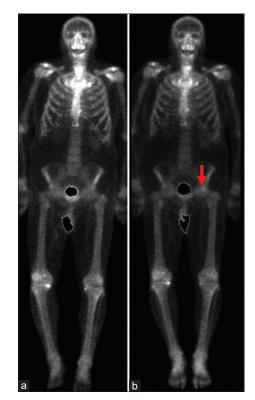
(a) Planar, whole-body ^{99m}Tc-methylene diphosphonate bone scan image from 6 months before ¹⁸F-DCFPyL-positron-emission tomography/computed tomography imaging demonstrates multifocal degenerative changes, but no suspicious uptake that would suggest osseous metastatic disease. (b) Planar, whole-body ^{99m}Tc-methylene diphosphonate bone scan image obtained contemporaneously with the ¹⁸F-DCFPyL-positron-emission tomography/computed tomography demonstrates new uptake in the left hip (red arrow), raising the possibility of a new metastatic bone lesion at this site
